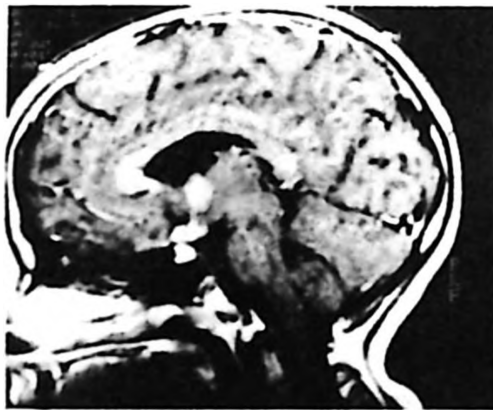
MRI of the brain on admission demonstrating a suprasellar mass (Case 7).
